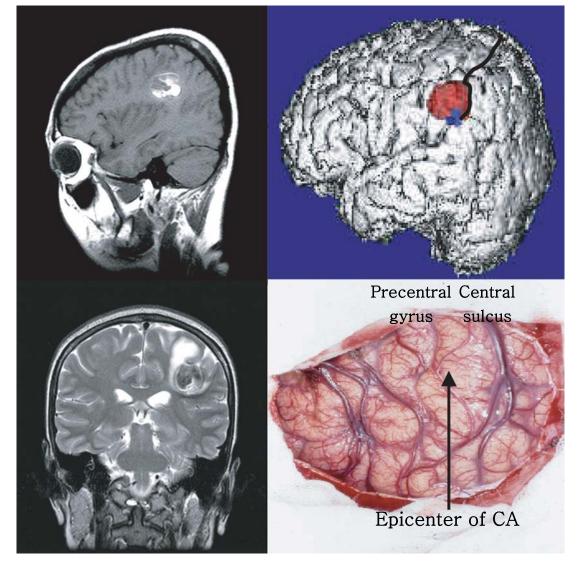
(Left) T1 sagittal and T2 coronal MR images showing the subcortical CA in left precentral gyrus. (Right) Created MR 3D-rendering image showing the lesion and adjacent cortical anatomy. We could identify the epicenter of CA by comparing the operation field with 3D-rendering image
